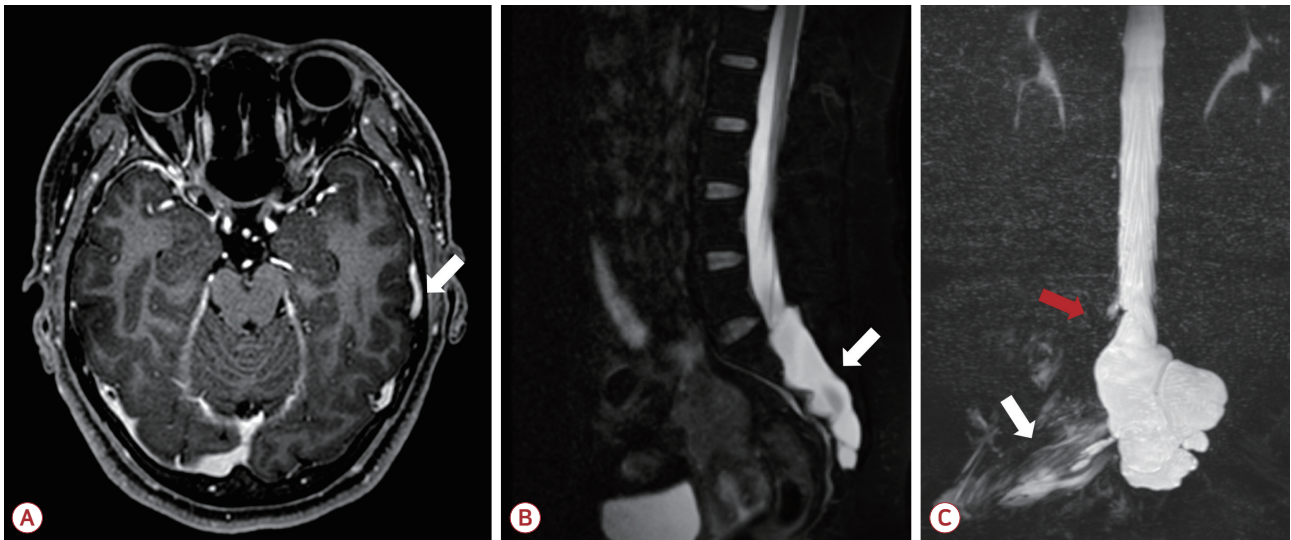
(A) The MRI findings of a 52-year-old woman indicate a small subdural effusion in the left parietal convexity (white arrow), as shown in the fluid attenuated inversion recovery image. (B) T2-weighted sagittal images of the lumbar spine non-contrast myelogram display an underlying intrasacral meningeal cyst (white arrow). (C) The sagittal maximum intensity projection reconstruction image of the lumbar spine non-contrast myelogram demonstrates sacral dural leak (white arrow) and extradural cerebrospinal fluid along the right piriformis muscle (red arrow). MRI; magnetic resonance imaging.
